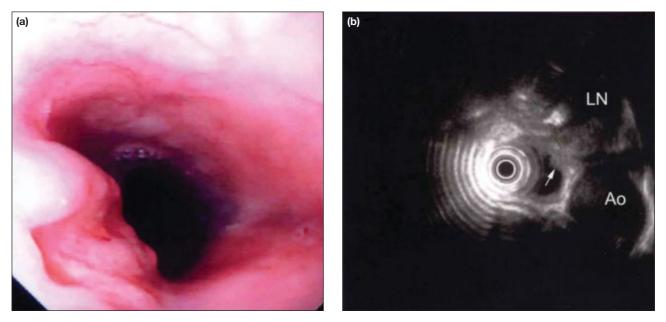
(a) Endoscopic view showing an ulcerohypertrophic lesion in the mid-oesophagus. (b) Endoscopic ultrasonography revealing an extramural lymph node with central hypoechogenicity and calcifications (LN) adjacent to the aorta (Ao). There is no border echo between the lymph node and the adjacent oesophagus, and the adjacent oesophageal wall appeared thickened with indistinct layer differentiation (arrow)
